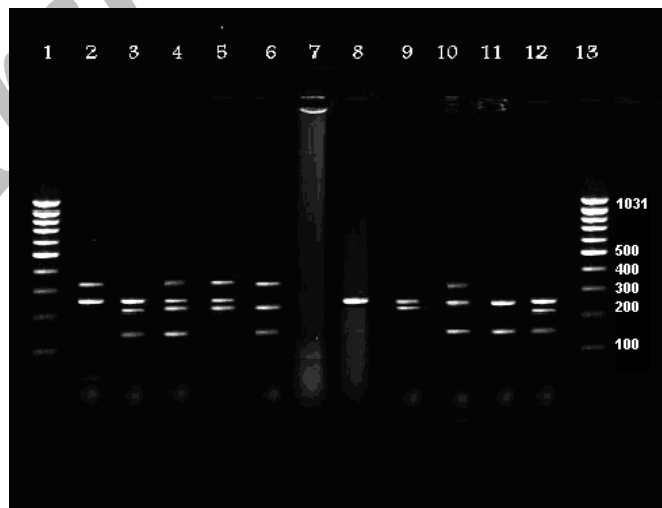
Detection of CT, MH and UU from Clinical Samples by Multiplex PCR. Lane 2,3,4,5, 8,9,10,11,12 clinical samples: Lane 2 MH, Lane 3,12 CT+UU, Lane 4 MH+CT+UU, Lane5 MH+CT, Lane 8 negative sample (β - globin), Lane 9 CT, Lane 10 MH+UU, Lane 11 UU, Lane 1,13 100bp DNA Ladder, Lane 6 standard bacterial strains, Lane 7 negative control
